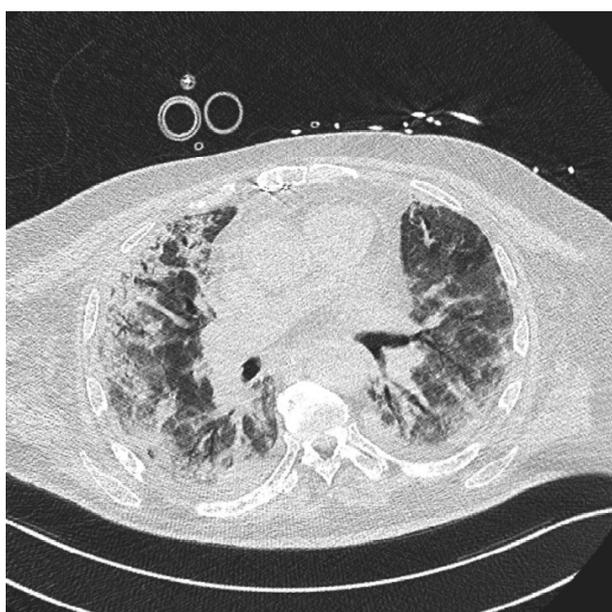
CT-scan of the thorax on April 29, 2020 (day 27 after ICU admission) showing Covid-19 disease progression, but complete resolution of the pneumomediastinum.
